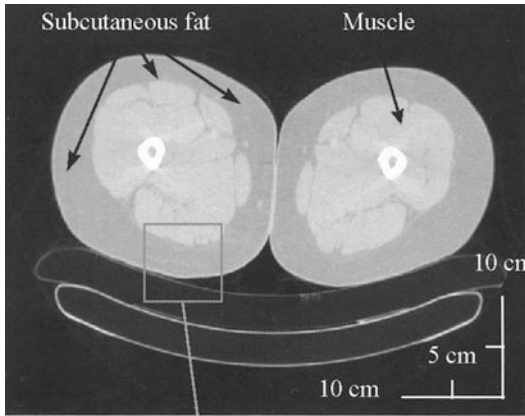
Computed tomography cross-section of both thighs (Courtesy of Prof. Joffre, Radiology Department, Rangueil University Hospital, Toulouse, France)
